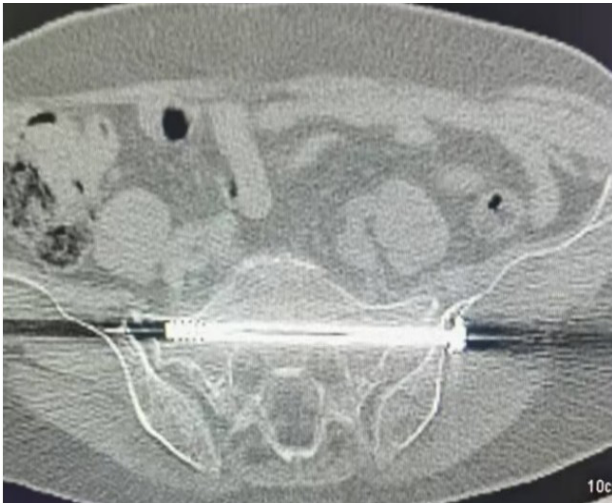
CT scan of screw position after sacroiliac joint screw insertion.
